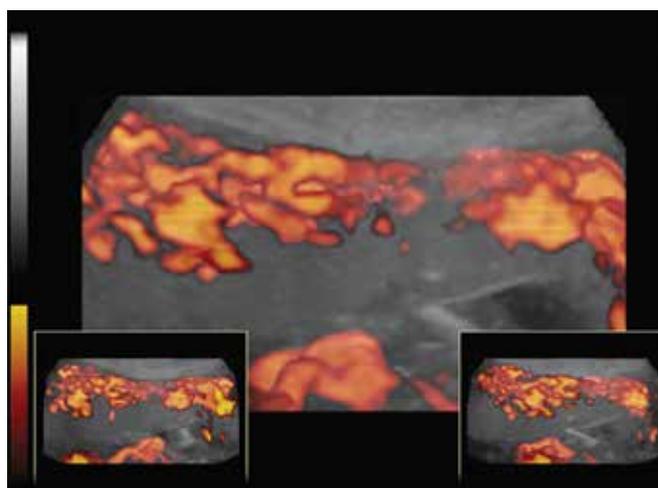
Another example of 3D power Doppler reconstruction of the normal placental blood flow
